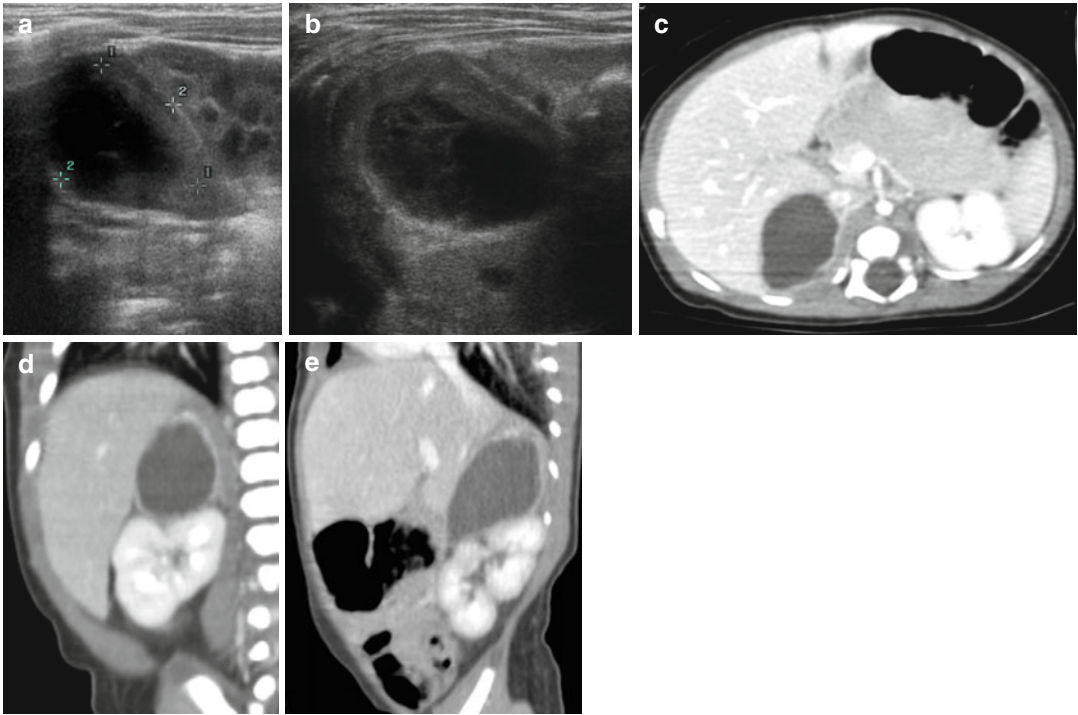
(a) Ultrasound performed with linear high-frequency probe shows an inhomogeneous and enlarged right adrenal gland within internal echoes and fluid. (b) Two weeks later US still shows a fluid-corpusculated mass with thickened walls. (c) Axial contrast-enhanced
